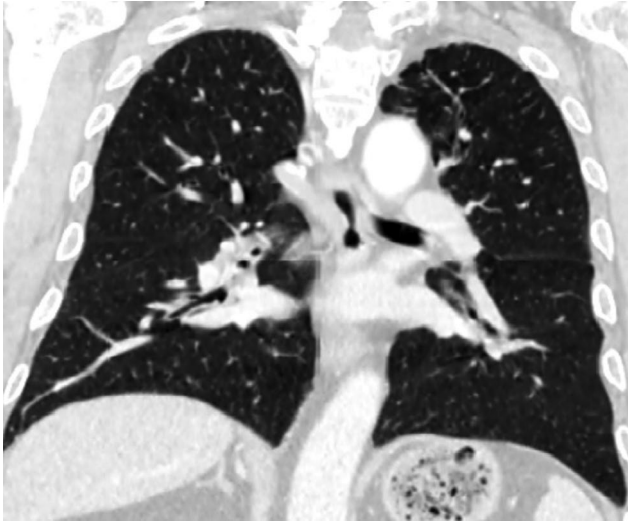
The patient's thorax computed tomography image.
